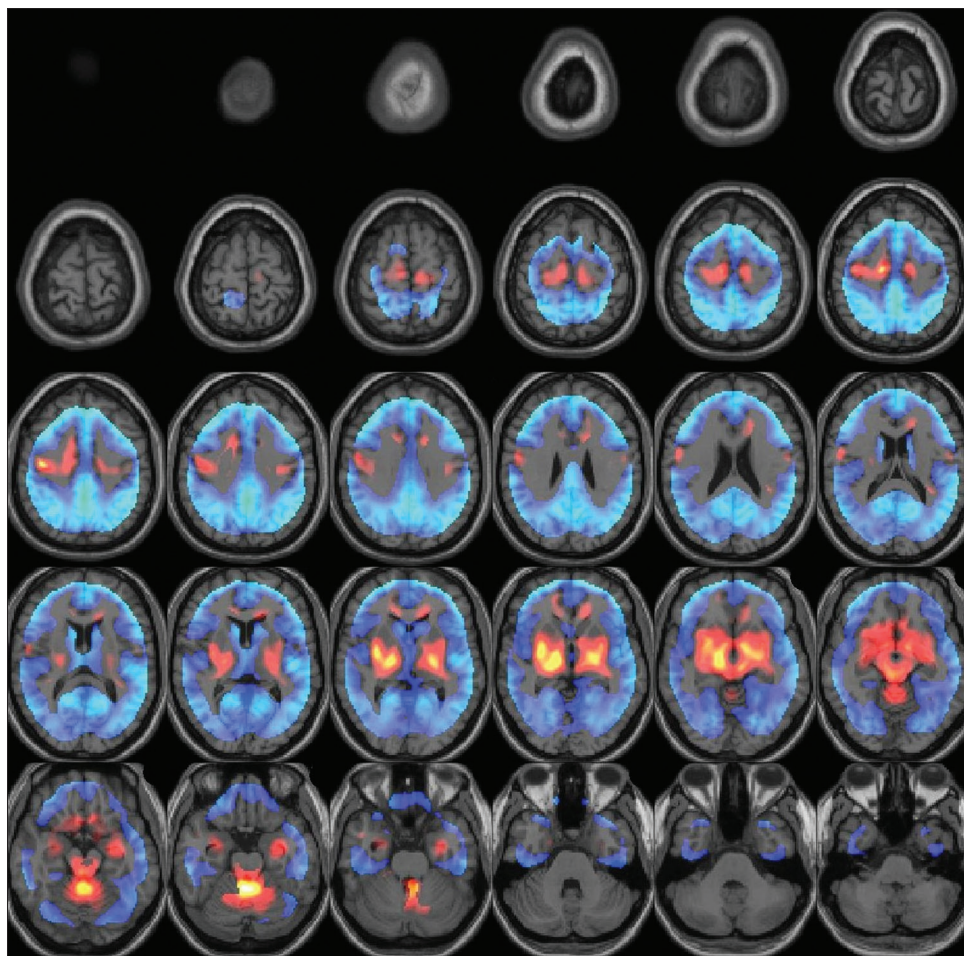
SPM images co-registered to a normal axial MRI showing the areas of hypometabolism (Blue) and hypermetabolism (Red)
